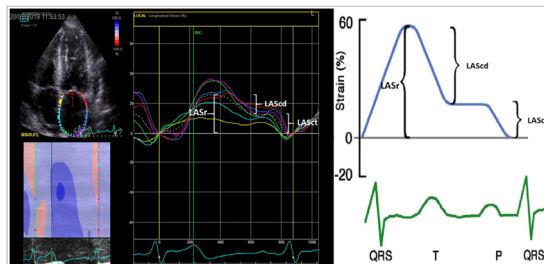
LA strain data. Left panel: Two-dimensional speckle tracking echocardiographic image of the left atrium (LA). Middle panel: LA strain curves for the period of diastole. Right panel: LA strain curves for the period of systole. LASr indicates LA reservoir strain, LASc indicates LA conduit strain, and LASct indicates LA contractile strain.
